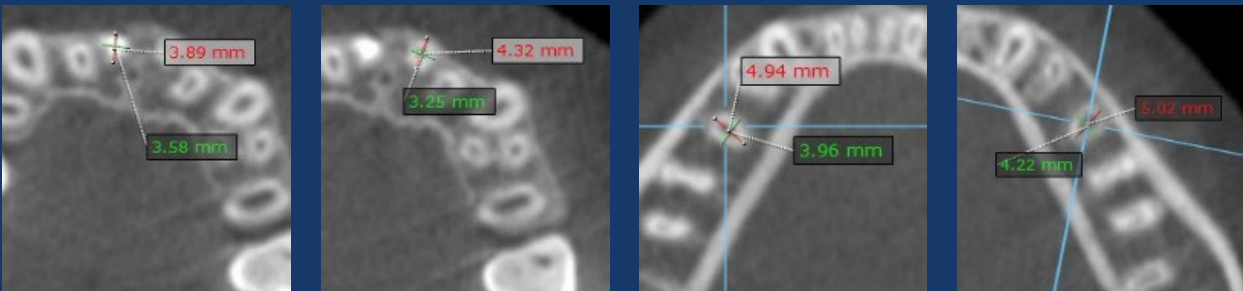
CBCT images to determine the size of the ankylosed teeth to be removed (A and B) and the size of the donor premolar teeth (C and D)
